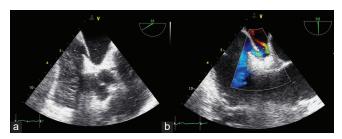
Transesophageal echocardiogram shows a large PFO. Panel A; right-to-left shunt after agitated saline solution. Panel B Aliasing at color Doppler. PFO = Patent forame ovale
